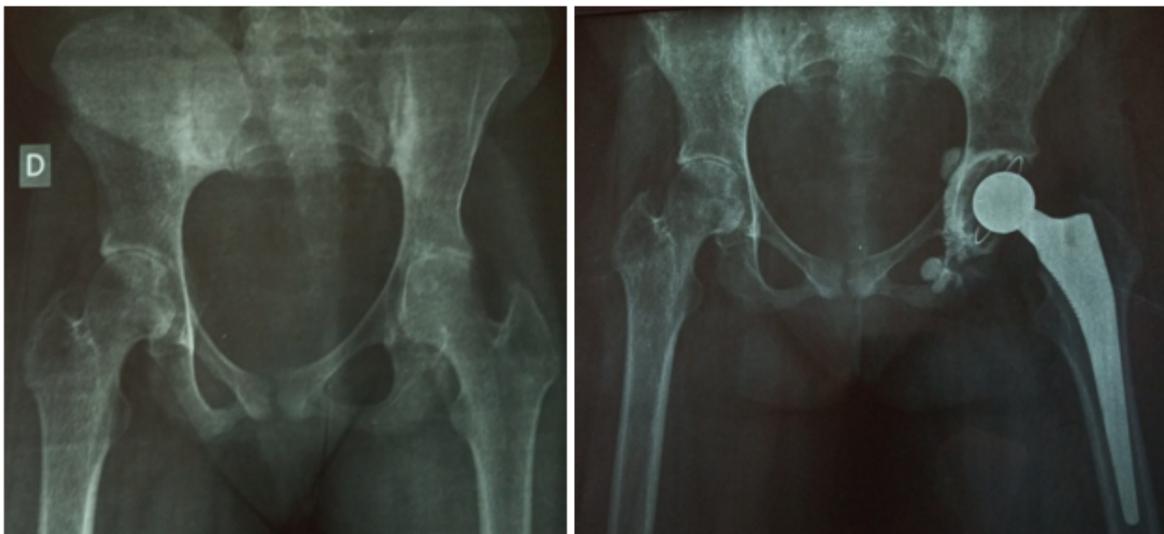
2a: AP pelvis x-ray: Kellgren and Lawrence stage 3 left hip osteoarthritis.
